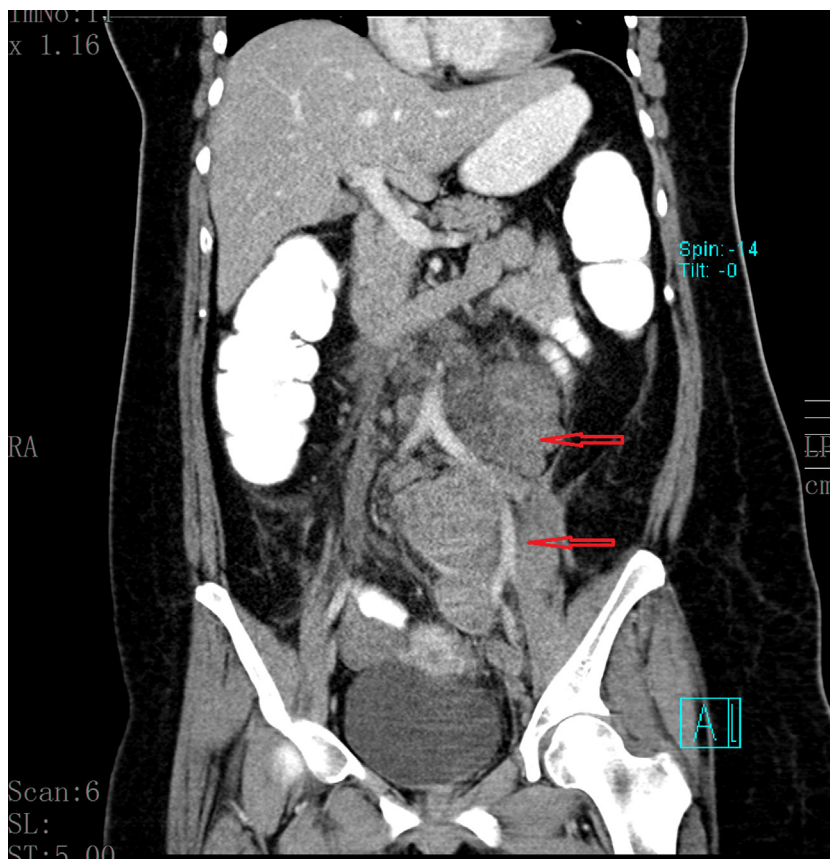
A 10 × 9 cm cystic mass surrounding left iliac artery appearance on coronal computed tomography (red arrow).
